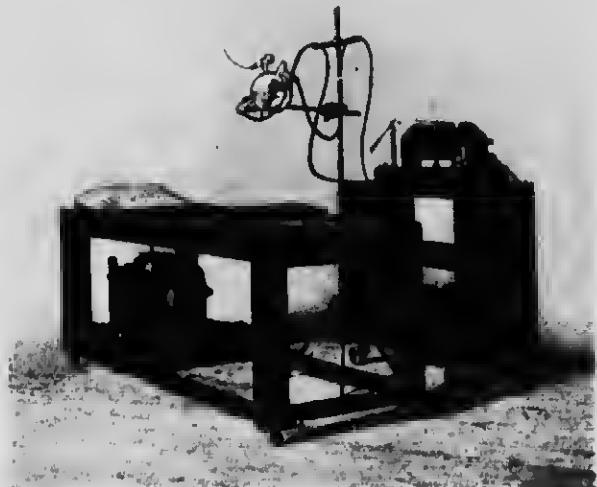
A SIMPLE COMPLETE X-RAY FITTING. Consisting of a small coil on a portable stand, with accumulators beneath. It is worked by a platinum brake. Two insulated cables lead from the secondary terminals, over a spreading bar to an X-ray tube. In this position the patient lies on the couch and the plate is placed on a flat board beneath him. A fluorescent screen and a pair of X-ray-proof gloves are lying on the couch. A tube box is beneath the couch, and can of course be used instead of the stand.
